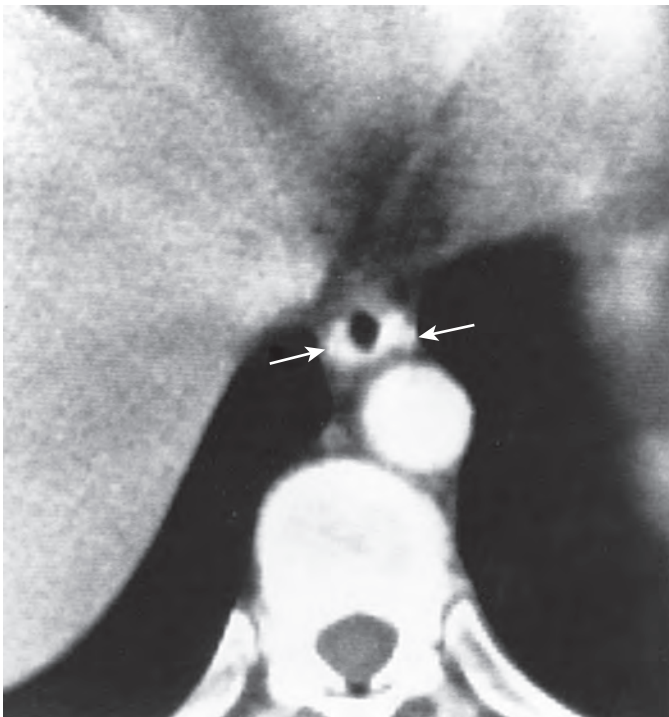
Esophageal varices on CT. Axial contrast-enhanced CT scan shows dense enhancement of the varices (arrows). (Courtesy Robert A. Halvorsen, MD, San Francisco.)
